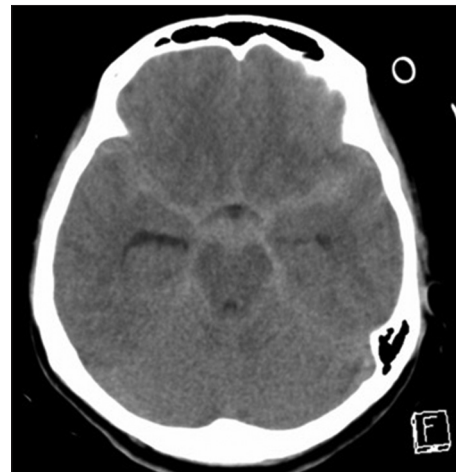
Noncontrast axial computed tomography scans taken at presentation showing diffuse subarachnoid hemorrhage and mild ventriculomegaly
